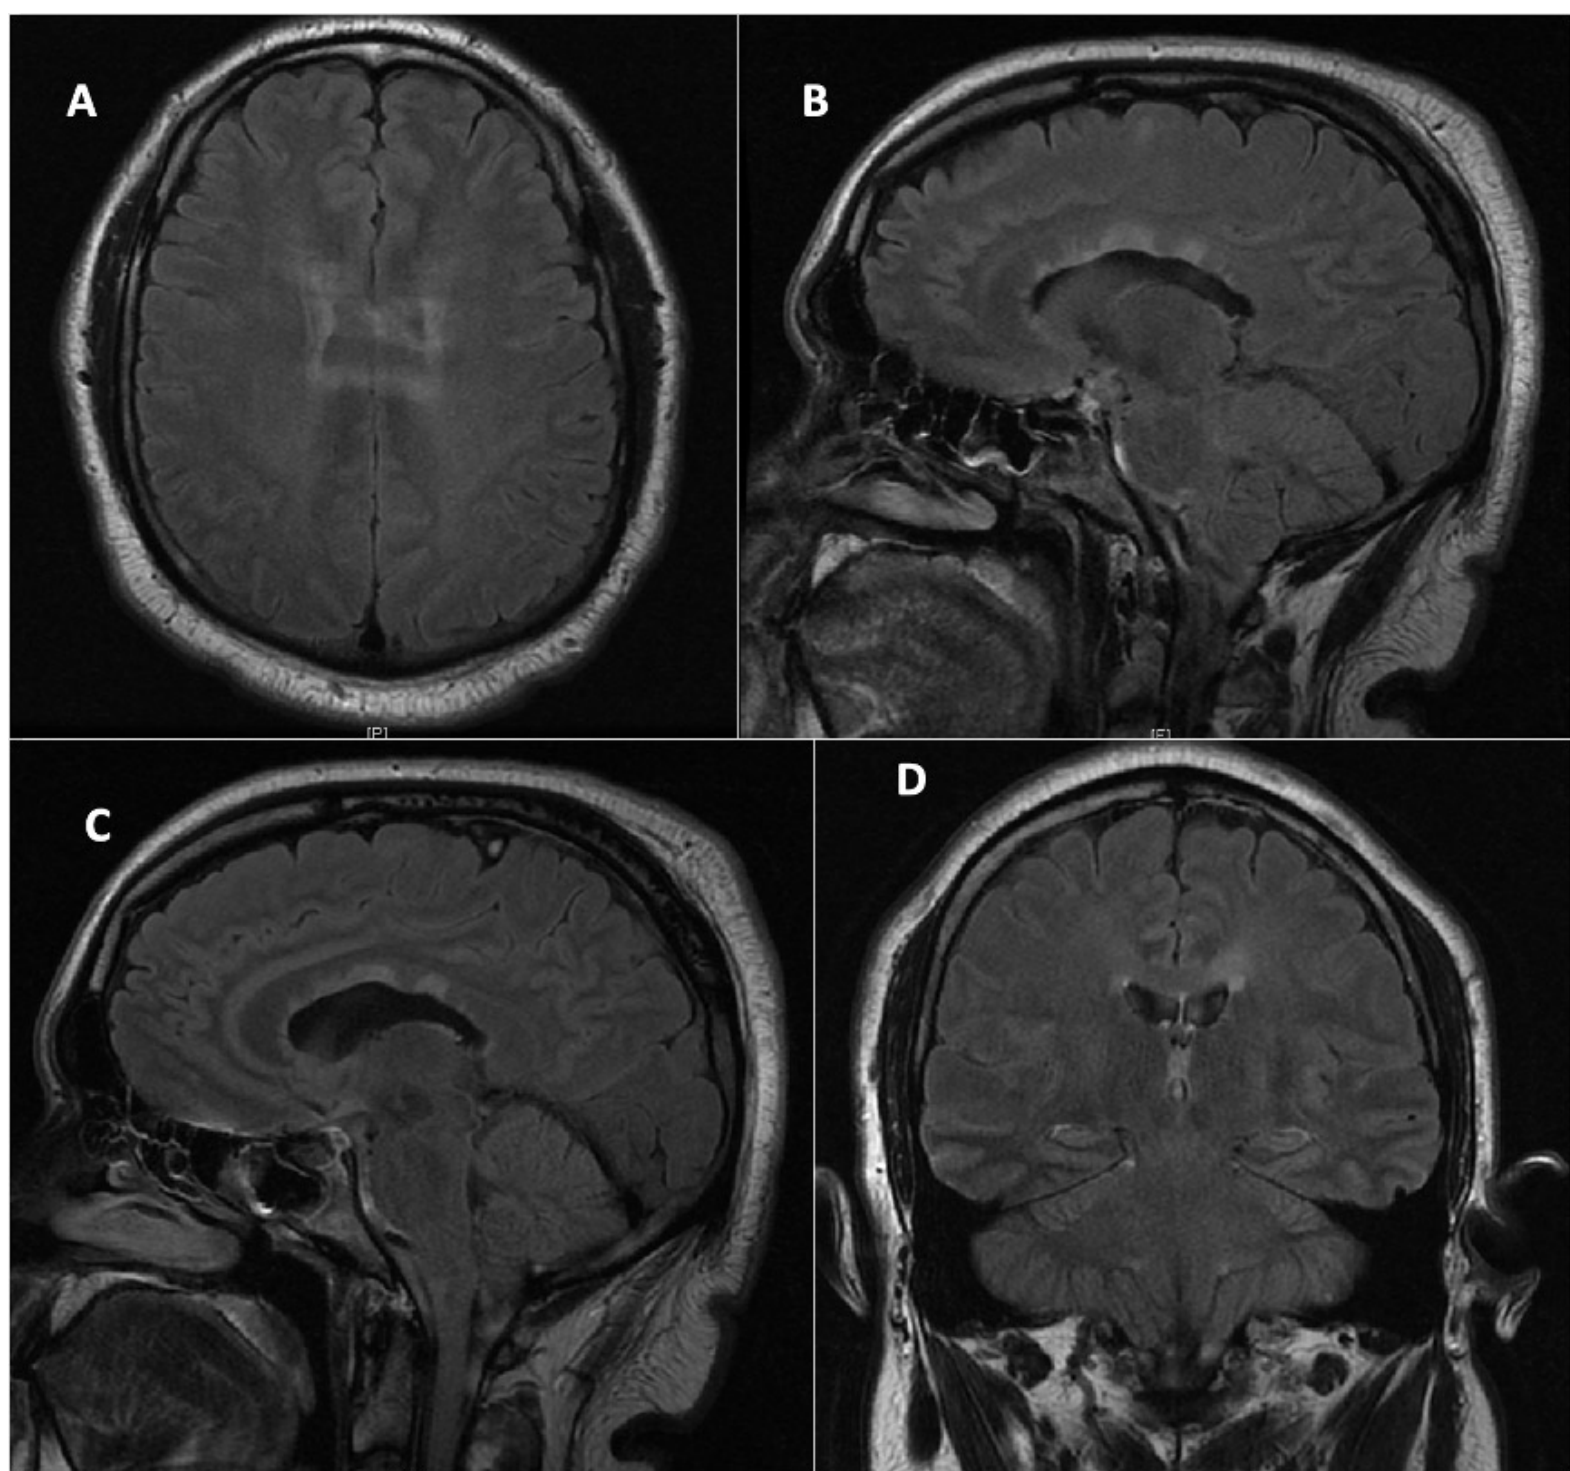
Initial MRI showing hyperintense corpus callosal and periventricular lesions
